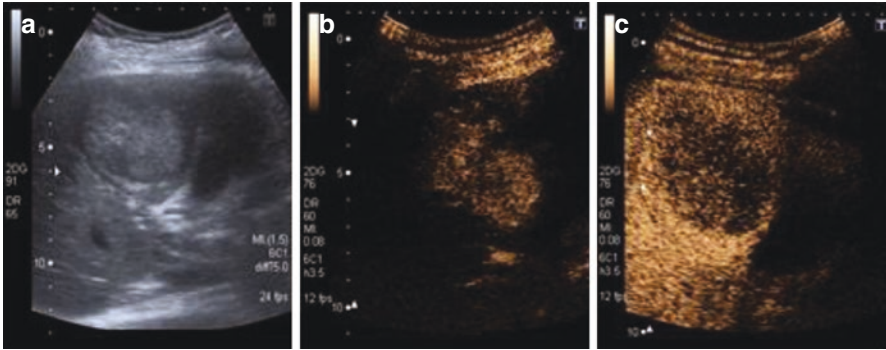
(a) Ultrasound image showing a 5 cm lesion within the right lobe of the liver. Contrast-enhanced ultrasound after administration of IV contrast showing (b) early and heterogeneous enhancement of the lesion at 13 s and (c) a rapid washout. The absence of uniform or continuous peripheral enhancement is highly suspicious of a malignant lesion. The early arterial enhancement and rapid wash out is characteristic of a HCC
